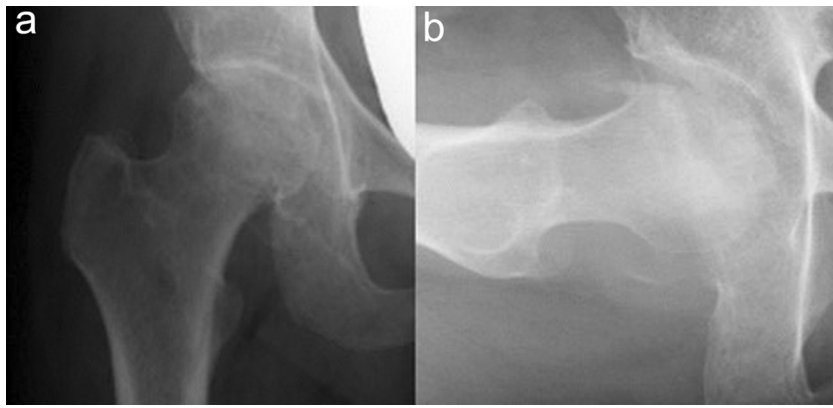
Initial (a) anteroposterior and (b) lateral radiographs of the right hip showed osteoarthritis with joint space narrowing and collapse of the weight-bearing surface of the femoral head (stage 4, Association Research Circulation Osseous [ARCO] staging system).
